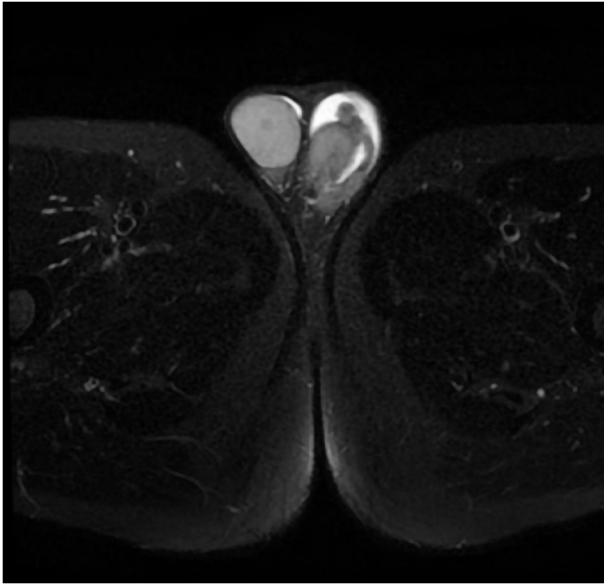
Left testis on 1.5T MRI with diffusion-weighted imaging. A round mass was visible above the left testis, with fluid signal around the testis.
